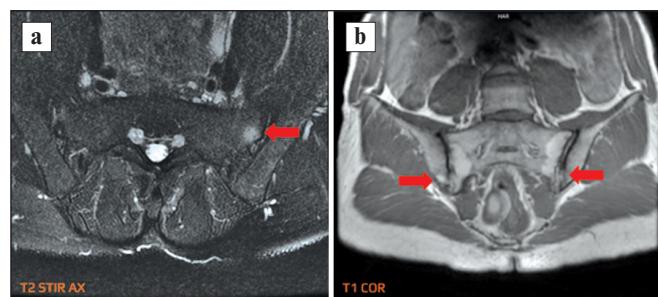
MRI of the sacroiliac joints (SIJs) using STIR (a) and T1-weighted sequences (b). Arrows indicate lesions: hyperintense area – bone marrow edema (a); erosions and fat metaplasia (b), typical for AS
